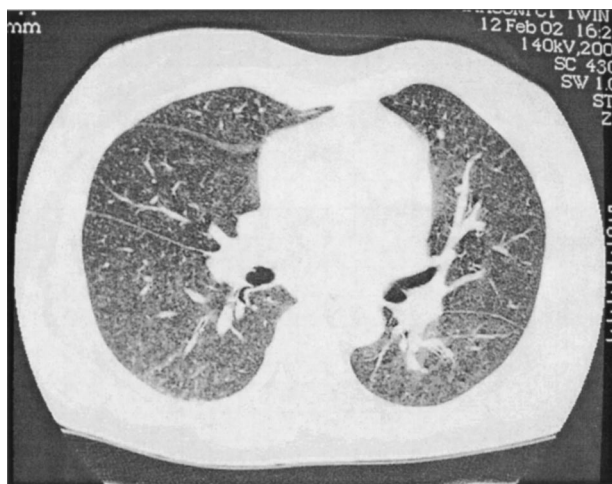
High-resolution lung CT showing bilateral and diffuse ground-glass opacities.
